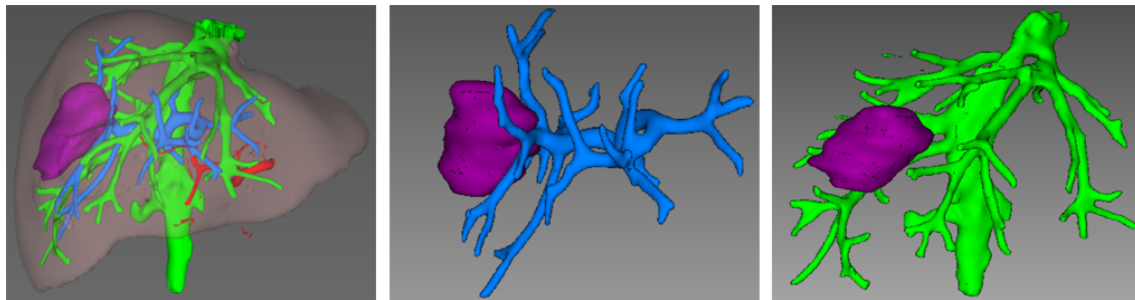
Preoperative 3D-CT reconstruction.
